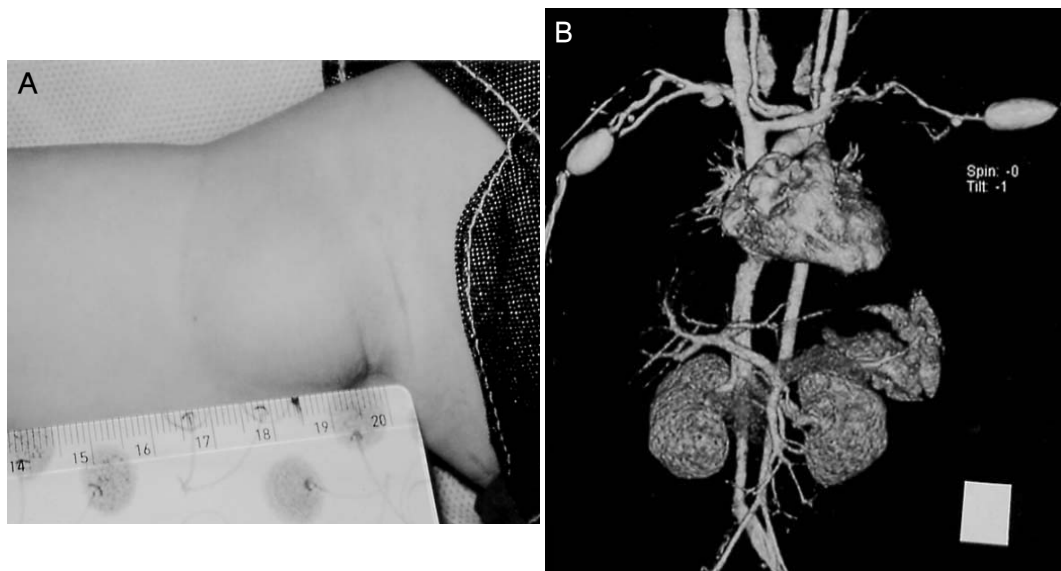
(A) Pulsatile axillary mass at the right axilla is shown. (B) Multi-detector computed tomogram clearly shows axillary arterial aneurysms.
